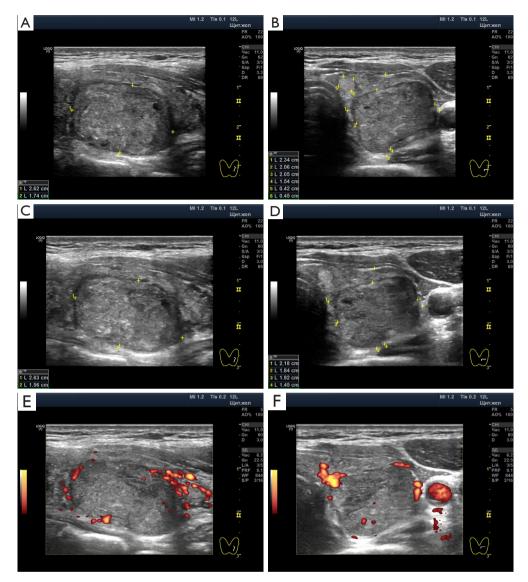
Thyroid nodule at the substage of Moderate Wasting. The patient is 51 years old, hypothyroidism, autoimmune thyroiditis. During control measurements after 3 years, the size and structure of the nodule changed very little. Fine needle biopsy was performed twice. In both cases, benign signs with phenomena of destruction and proliferation were identified; Bethesda 3. (A,B) December 2020. Longitudinal and transverse projections of the left lobe of the gland in gray scale. In a nodule 26.2×20.5×15.4 mm, moderately hypoechoic tissue is visible, among which there are isolated significantly hypoechoic and isoechoic lobules. (C,D) January 2024. Nodule 26.3×19.2×14.5 mm. Longitudinal and transverse projections of the left lobe of the gland in gray scale. Moderately hypoechoic tissue is visible, among which there are isolated significantly hypoechoic lobules. (E,F) January 2024. Power Doppler mode. The blood flow of the nodule is inactive, mainly along the perimeter.
